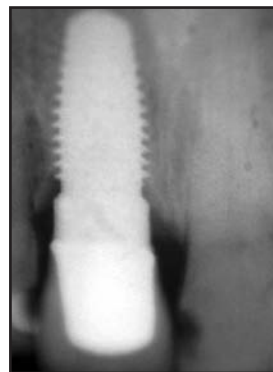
Postoperative radiograph following 2 years of function demonstrated continued healing and complete osseointegration.
